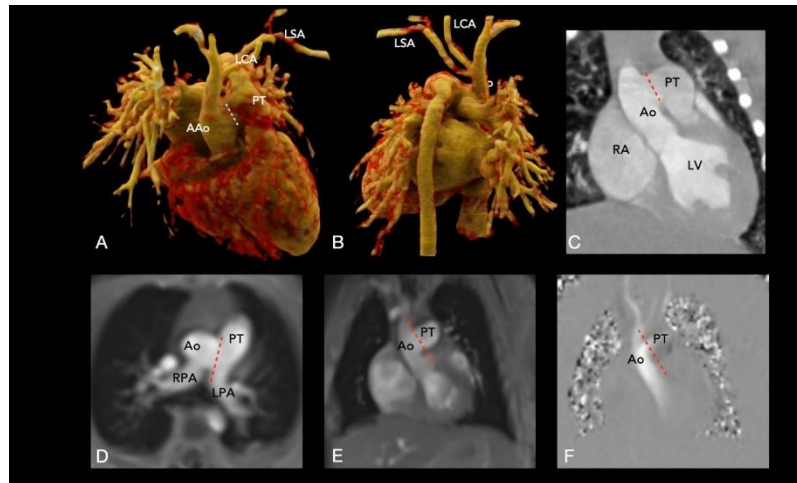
Top panel. Cardiac CT. A and B 3D volume rendering images showing type A interrupted aortic arch. C shows aortopulmonary window (dotted line). Bottom panel. CMR. Cine showing aortopulmonary window (dotted line) and anomalous origin of RPA from ascending Ao (D). E and F 2D phase contrast showing the shunt from Ao to PT.
